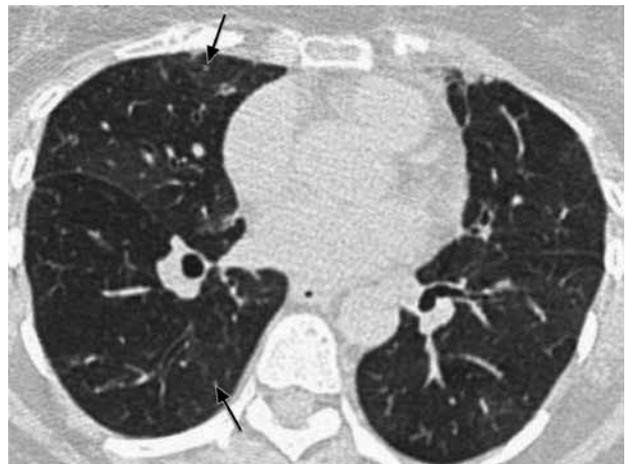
High resolution CT of the chest, where ground glass opacities and nodular lesions.
